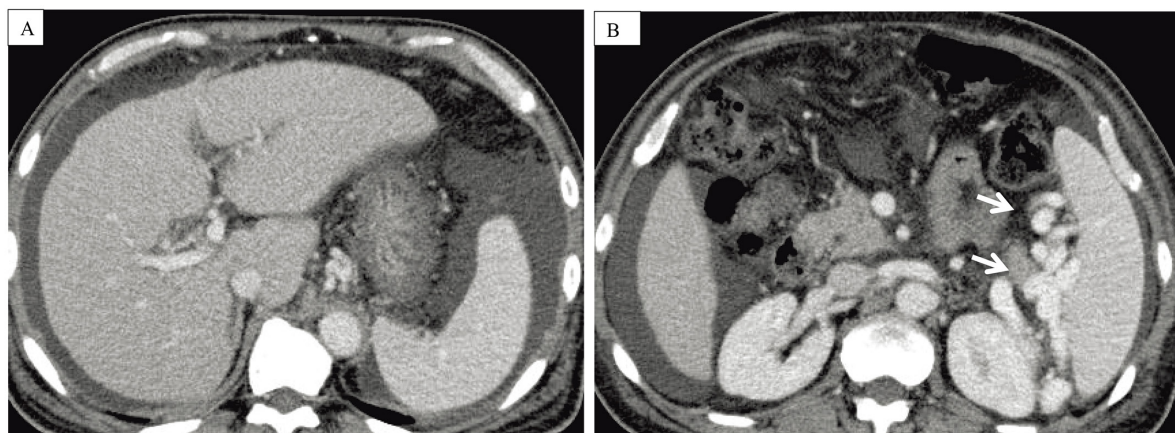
Pre-transplant computed tomography images.
